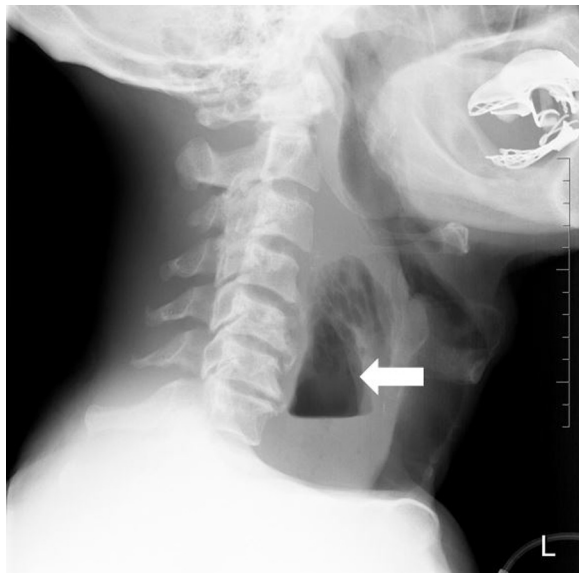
Lateral soft tissue neck x-ray study showing air–fluid level in a large retropharyngeal abscess (arrow).
